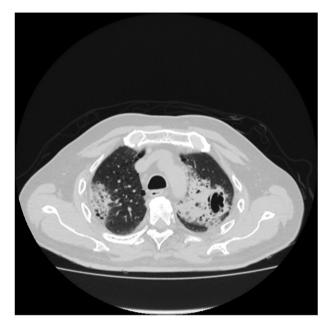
HRCT-Thorax showing bilateral consolidation with a cavity in left upper lobe.
